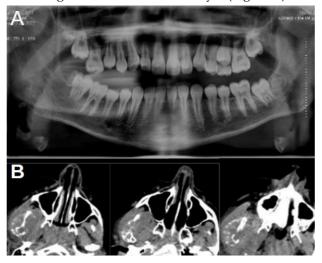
A-Panoramic radiograph and B-axial section CT images of the lesion showing sun-burst periosteal reaction.
